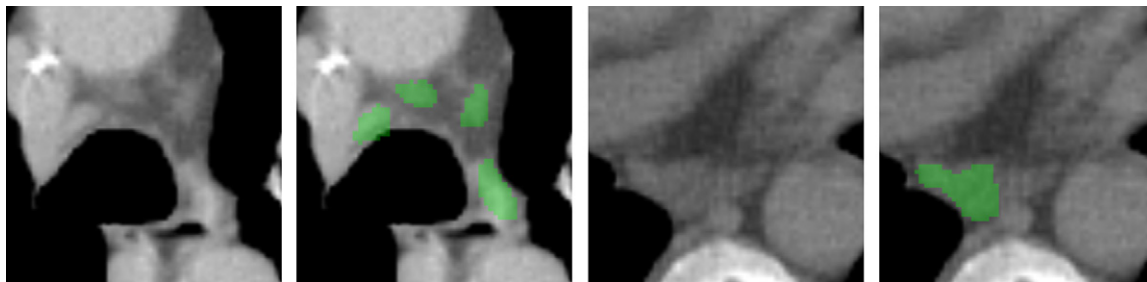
Two axial cross sections of CT volumes with expert-reviewed lymph node annotations (green).
